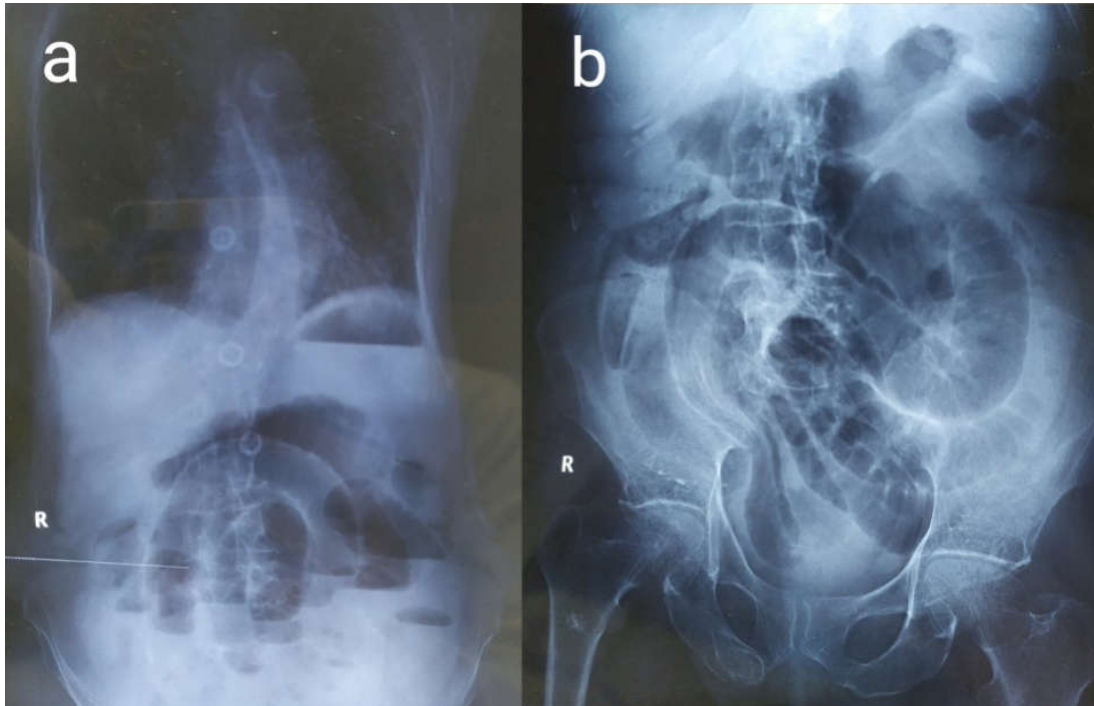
a. X-ray Abdomen erect depicting multiple air fluid levels b. X-ray Abdomen supine film demonstrating grossly dilated small bowel loops with absence of gas shadow in rectum
